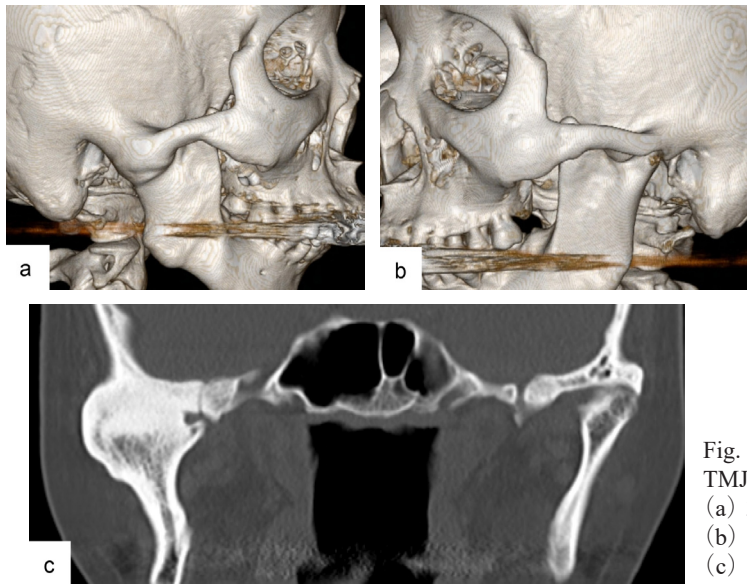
Preoperative CT showing a mass in the right TMJ, narrow joint space in the left TMJ.
